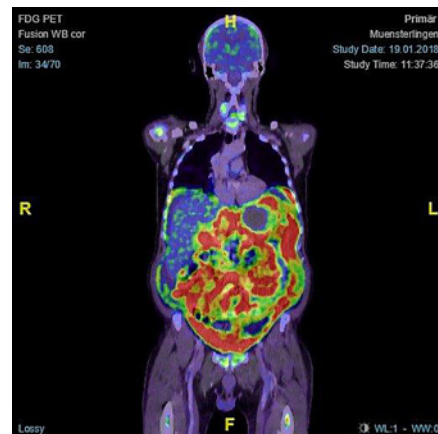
Image showing abdominal tumor mass prior to initiating therapy (FDG-PET-CT). Figure reprinted with kind permission of Thomas Kelly, Senior Physician Nuclear Medicine, Cantonal Hospital Münsterlingen, Münsterlingen, Switzerland.
